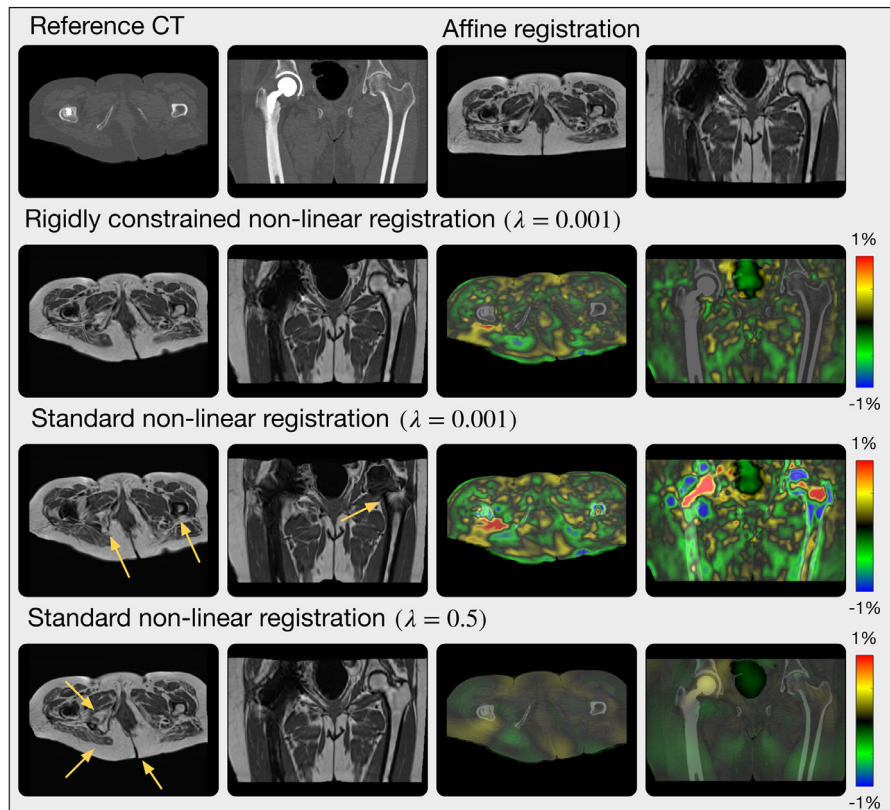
Example of registration results. The central axial and coronal views for the reference CT, the affinely registered MRI, the non-linearly registered MRI with and without the use of the rigidity constraints are reported. The coloured insets show the Jacobian determinant maps (in percentage of volume change) for each non-linear deformation. Results are displayed with the rigidly-constrained registration optimal regularisation weight ($\lambda = 0.001$) to showcase the sole effect of the rigidity constraints. The result of the optimal fully non-linear regularisation weight ($\lambda = 0.5$) is also shown. Yellow arrows point at areas where the standard non-linear registration fails to recover a good alignment. Differently from this latter, our rigidly constrained non-linear registration allows for more localised deformation and better soft tissue alignment while preserving the volume and shape of bones and implant.
